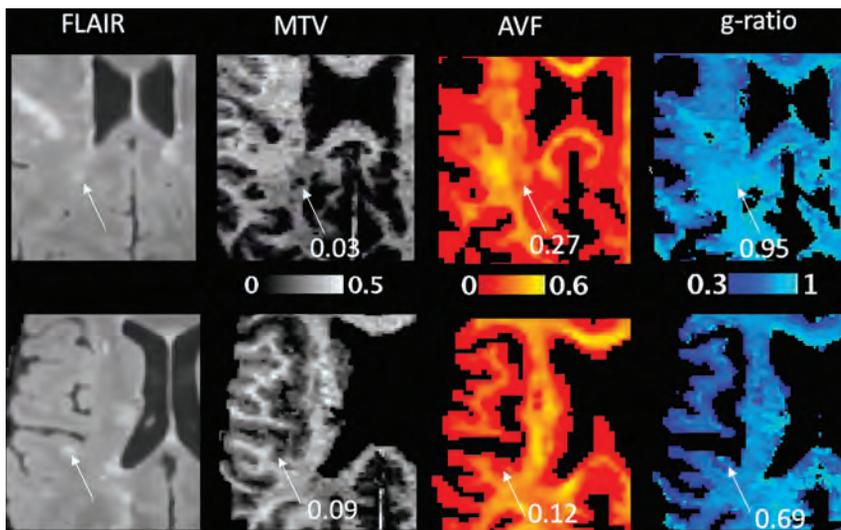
Representative axial T2-FLAIR image and maps of macromolecular tissue volume reflecting myelin content, axonal volume fraction, and g-ratio in a patient with RRMS. The upper row shows a lesion with an elevated g-ratio (0.95), indicating a greater degree of demyelination relative to axonal loss. The lower row shows a lesion with concordant axonal and myelin loss, which is reflected by a g-ratio similar to that of NAWM (0.69). For comparison, the conventional T2-FLAIR images do not demonstrate a discernible difference in contrast between the 2 lesions.
